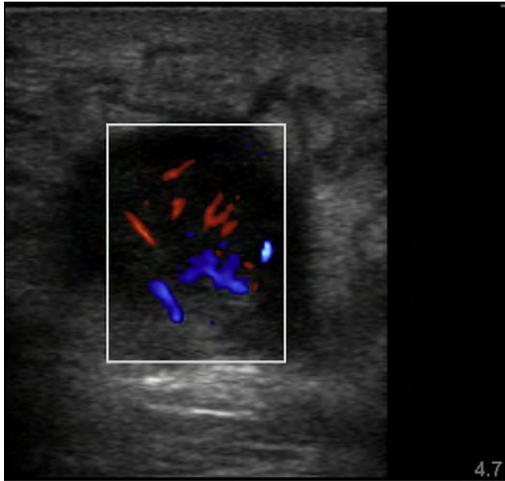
Evaluated for an abscess, this shows a Doppler flow pattern consistent with adenitis. Also noted are the surrounding cellulitic changes (cobblestoning). An abscess should not have Doppler signal within the cavity.
